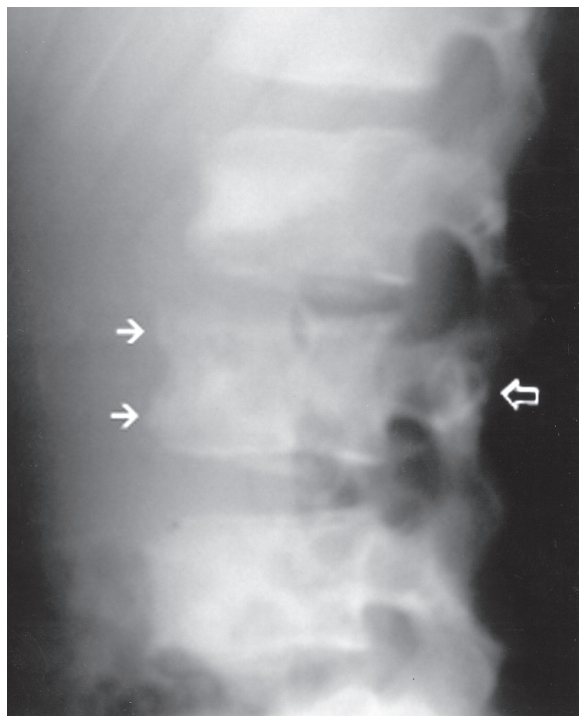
A) lateral radiograph shows anterior osteophytes (white arrows) and irregularity of the L-2 and L-3 endplates (open arrow) with heterogeneity of the vertebral bodies.
